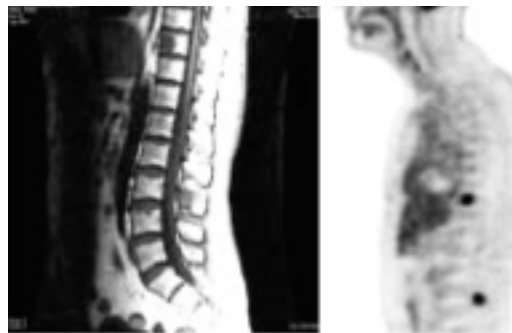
FDG-PET: Sagittal view of the spine.
